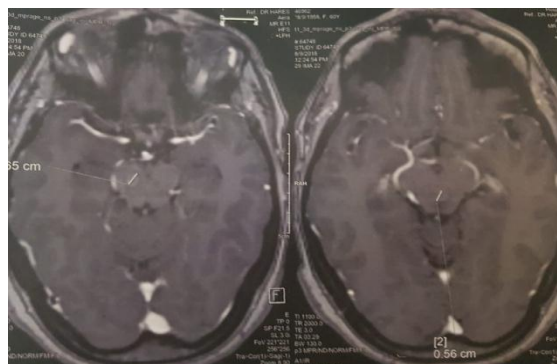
MRI, axial section: presence of two lesions with secondary annular contrast at the right cerebral peduncle and at the mesencephalic cap.
